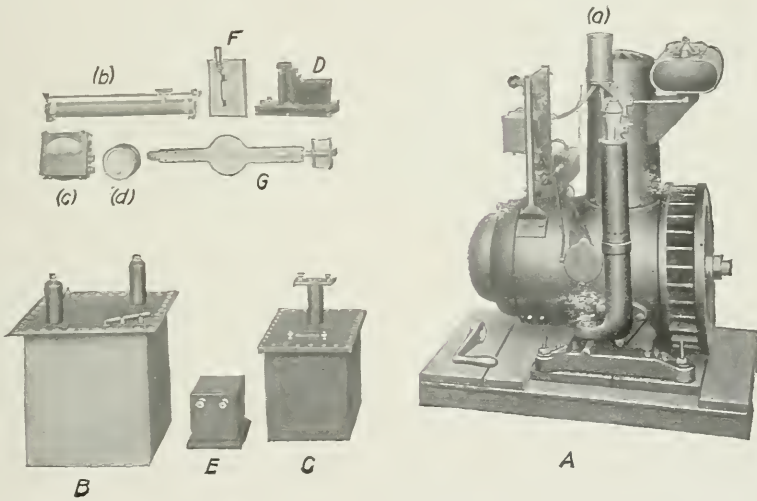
SEPARATE UNITS COMPRISING PORTABLE ROENTGEN RAY OUTFIT.
